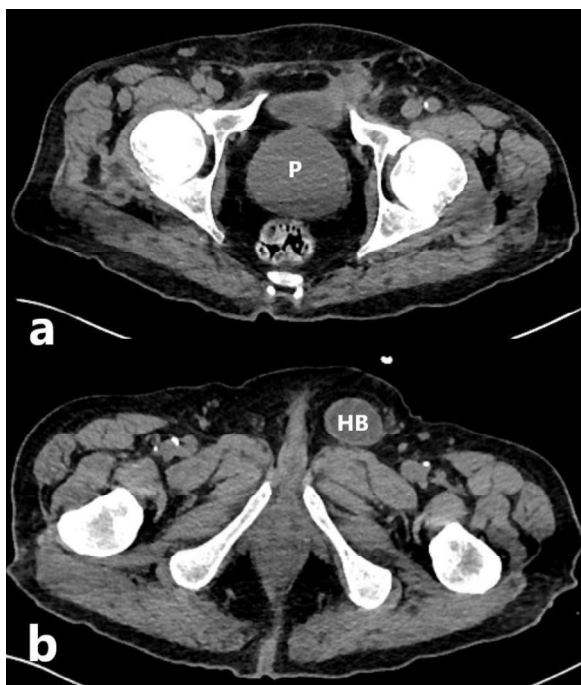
As a triggered factor big prostate (a), and left inguinal herniation (b) in axial CT image. Abbreviations; P: Prostate HB: Herniated bladder
